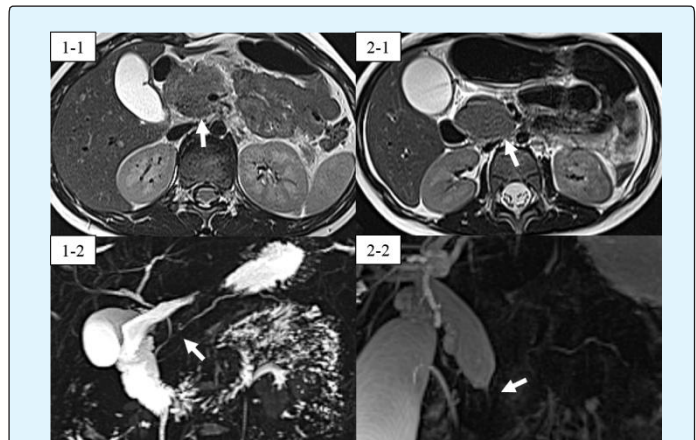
MRI results for case 1 and 2. 1-1 and 2-1 show a low T2 intensity mass-like effect at the pancreatic head (arrow). 1-2 shows partially obstructed pancreatic duct and distal common bile duct at the pancreatic head (arrows). 2-2 shows narrowing of the distal common bile duct at the level of the pancreatic head due to the mass-like effect (arrow).
